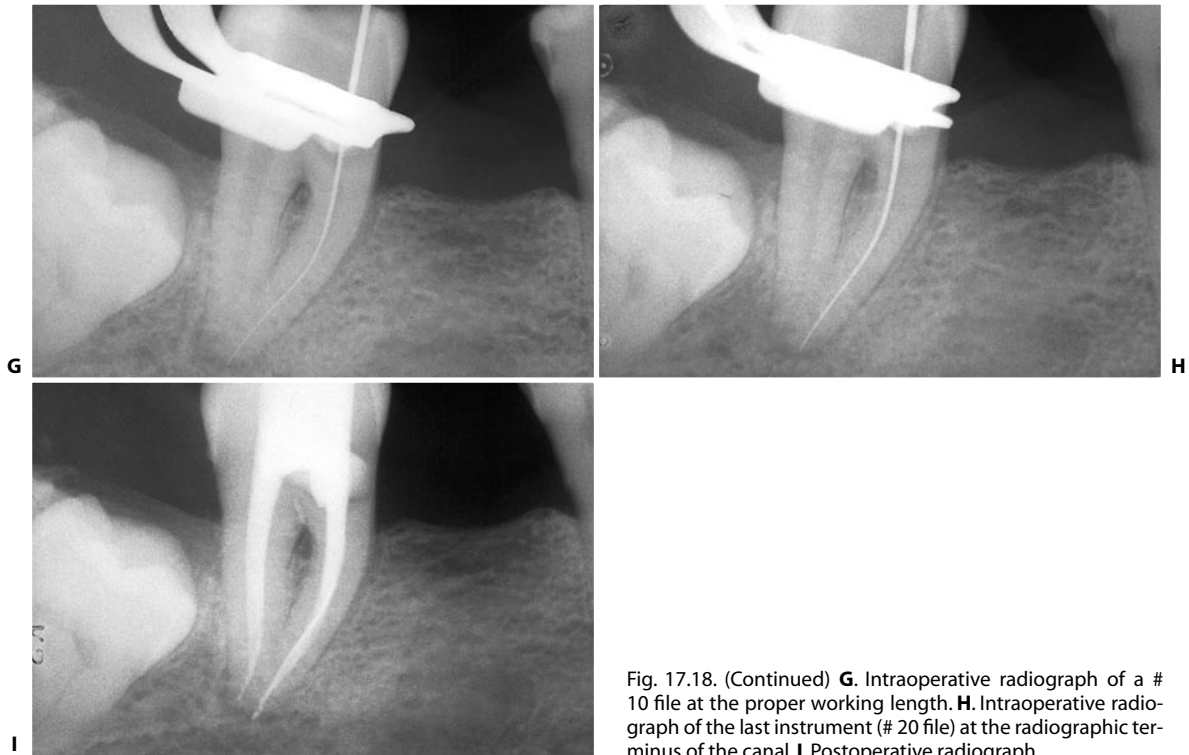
(Continued) G. Intraoperative radiograph of a # 10 file at the proper working length. H. Intraoperative radiograph of the last instrument (# 20 file) at the radiographic terminus of the canal. I. Postoperative radiograph.
